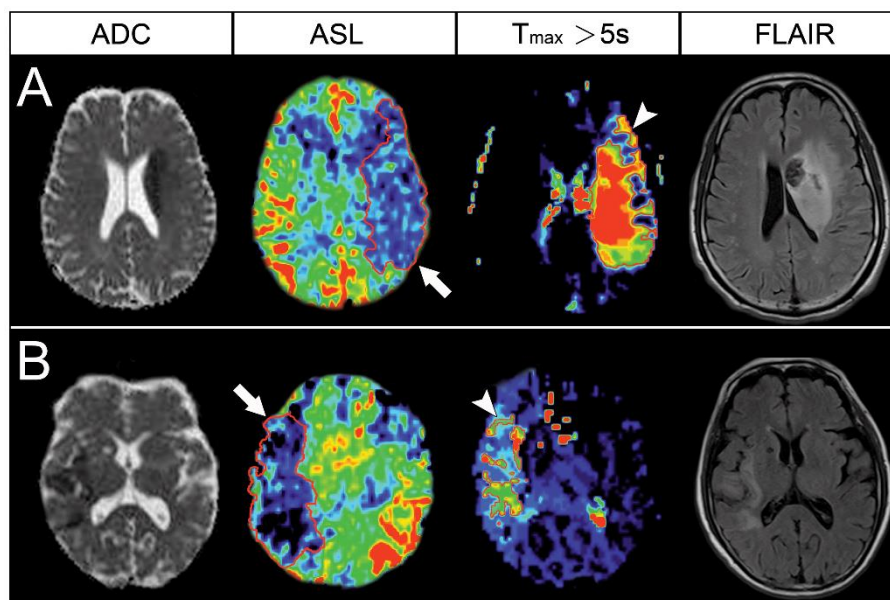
Comparison of ASL to DSC perfusion ( $T_{max} > 5s$ ), showing an overestimation of hypoperfusion, with DSC closer to final infarct volume on follow-up FLAIR
